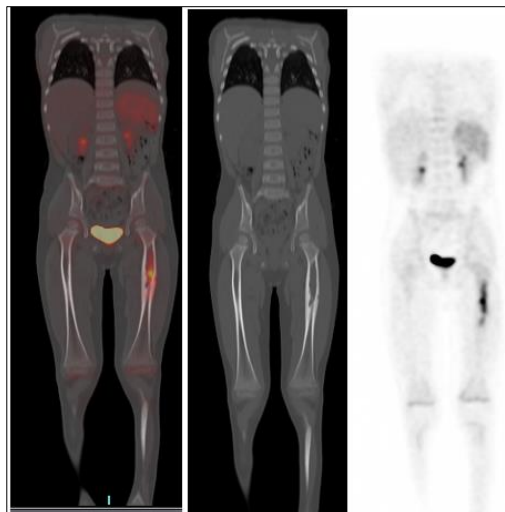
Coronal CT, PET Scan and PET CT both femurs showing left tibial lytic lesion with FDG uptake
